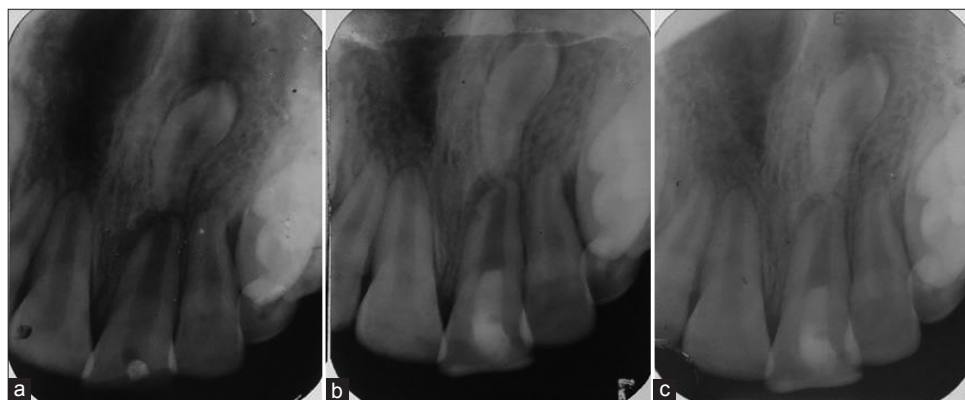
(a) Preoperative intraoral periapical radiograph. (b) Postoperative intraoral periapical radiograph at 6 months. (c) Postoperative intraoral periapical radiograph at 12 months
